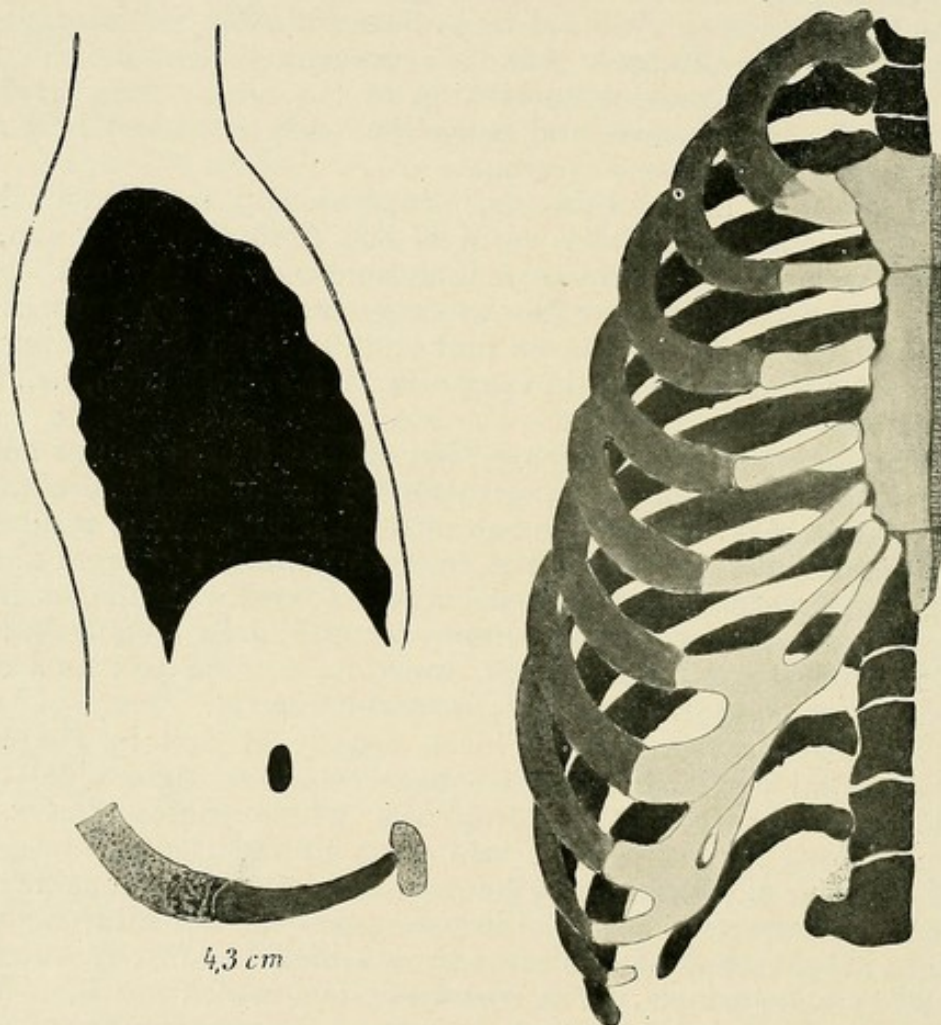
Normal thorax. Parasternal longitudinal section from a plaster cast. Transverse and longitudinal section of a normal costal cartilage of the average length of 4.3 cm. (According to W. A. FREUND.)
